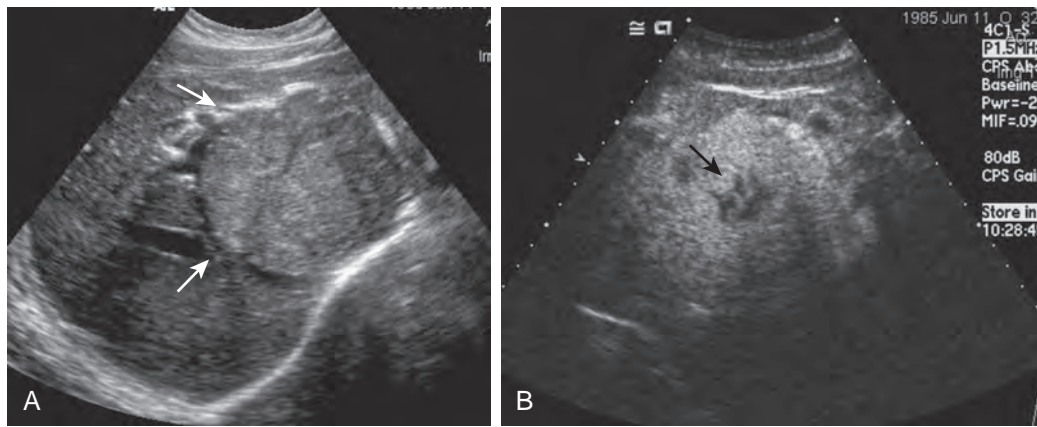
Focal nodular hyperplasia: ultrasound findings. A. Sonogram demonstrates a large lesion in the right lobe of the liver (arrows). B. Contrast-enhanced sonogram demonstrates early arterial enhancement of FNH; note that central scar shows no enhancement (arrow).
